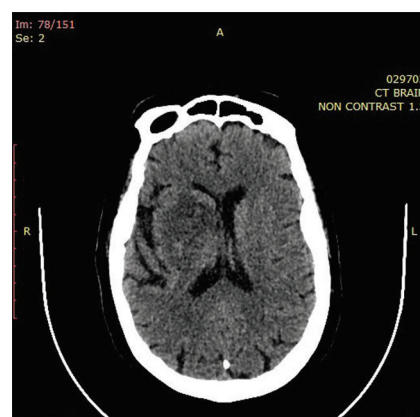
On the 24-hour follow-up CT after thrombolysis, there is a small infarction in the right basal ganglia
